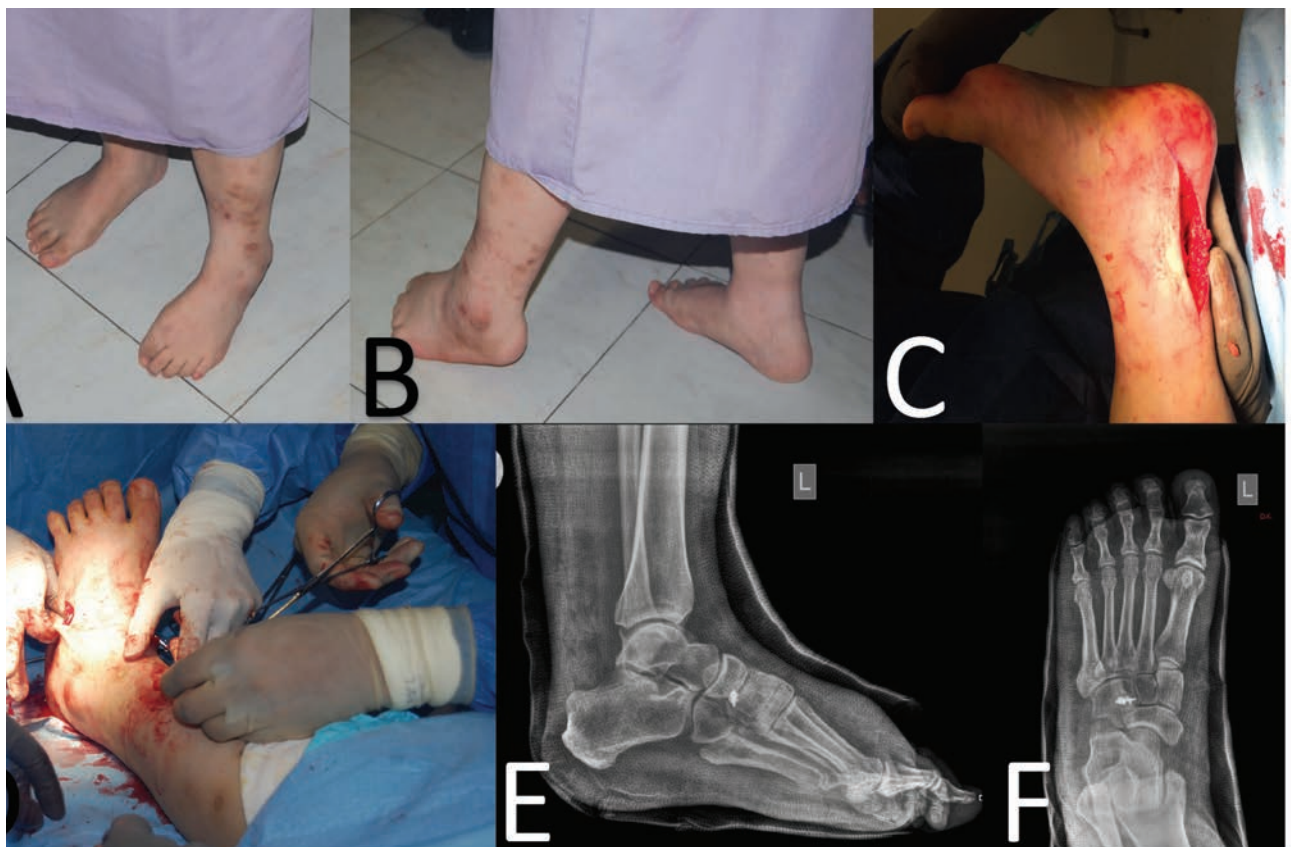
(A-B) Clinical images demonstrating equinovarus attitude of the foot and ankle. (C) Intra-operative image of open sagittal sliding tendo-Achilles lengthening and FHL tenotomy. (D) Intra-operative image demonstrating posterior tibial tendon transfer. (E-F) Immediate post-operative radiographs demonstrating good correction in each plane of the deformity.
